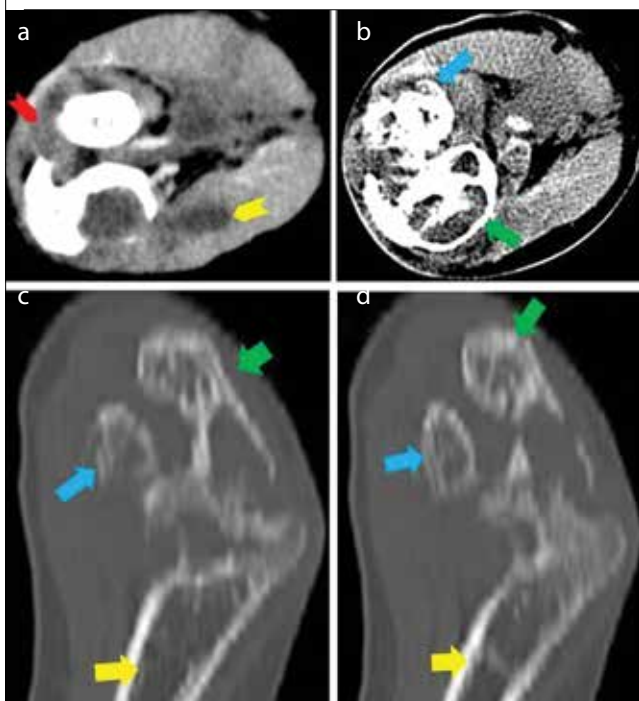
a-d. On CT of the left elbow, in the axial slices, (a) effusion was seen in the joint space (red arrow head), with locular collection extending to the soft tissue (yellow arrowhead), (b) the lytic areas were destroying the cortex in the proximal sections of the ulna (green arrow) and radius (blue arrow), and (c, d) on the coronal sections of the olecranon–distal humerus (yellow arrow), widespread lytic areas were destroying the cortex in the proximal sections of the ulna (green arrow) and radius (blue arrow)
